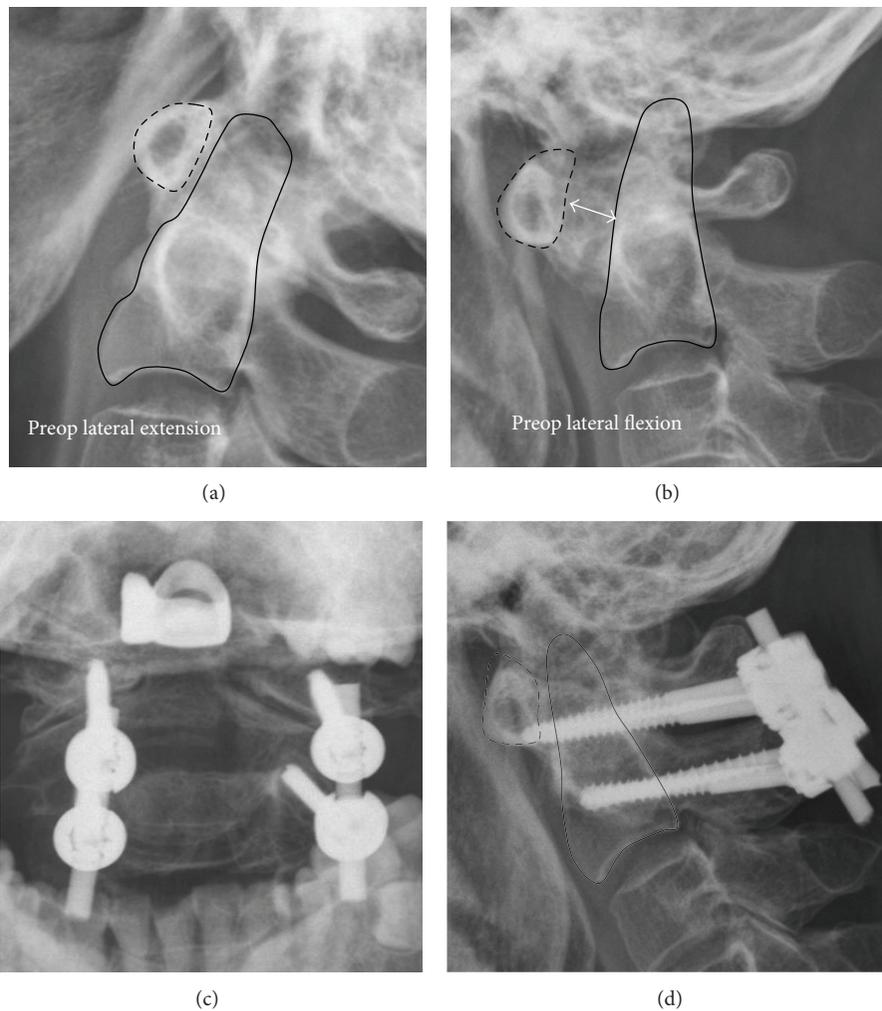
Preop dynamic lateral radiographs revealed AAI ((a) and (b)). The atlantodental interval 6 mm in flexion position (b) is measured (double-headed arrow). Postop radiographs revealed atlantoaxial fusion with LC1-PC2 system ((c) and (d)).
